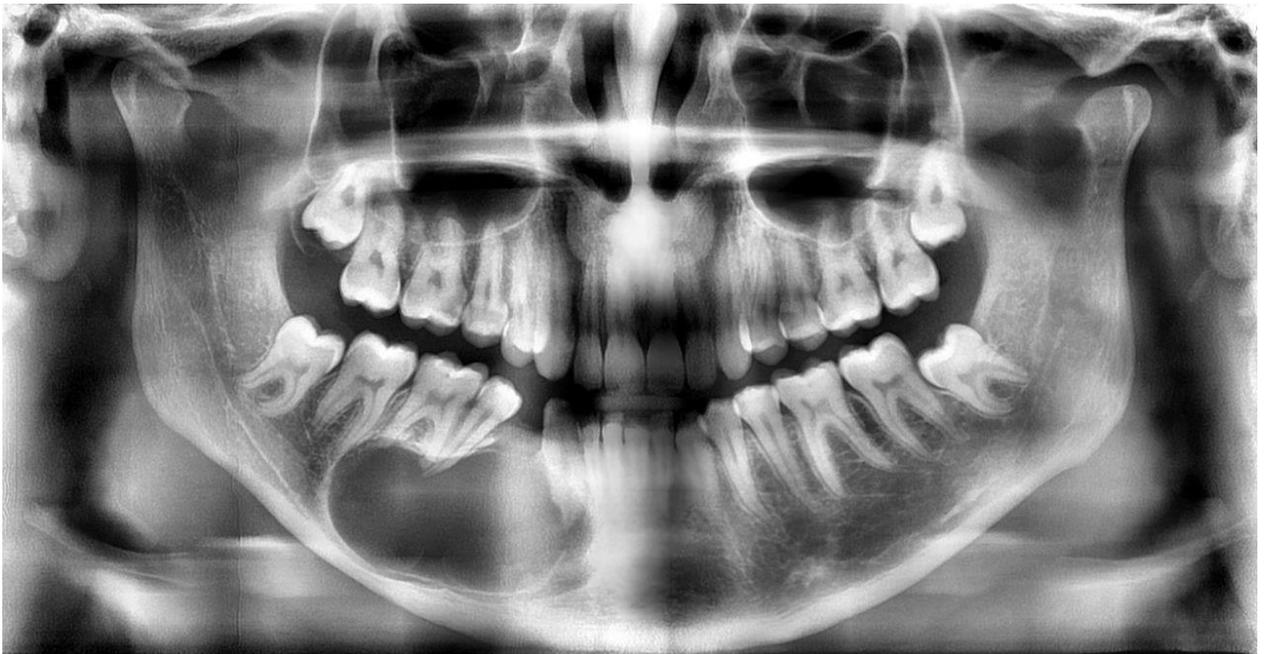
Orthopantomograms of patient K.P. Lower jaw radicular cyst measuring 9x4 cm in the area of 42-46 teeth.
